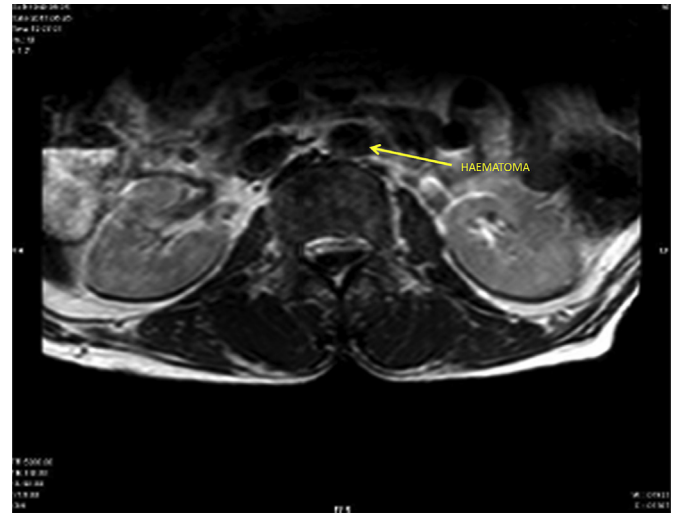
T2 weighted axial MRI image. This shows a spinal epidural hematoma at the level between D12–L1 thoracic spine with cord compression.
